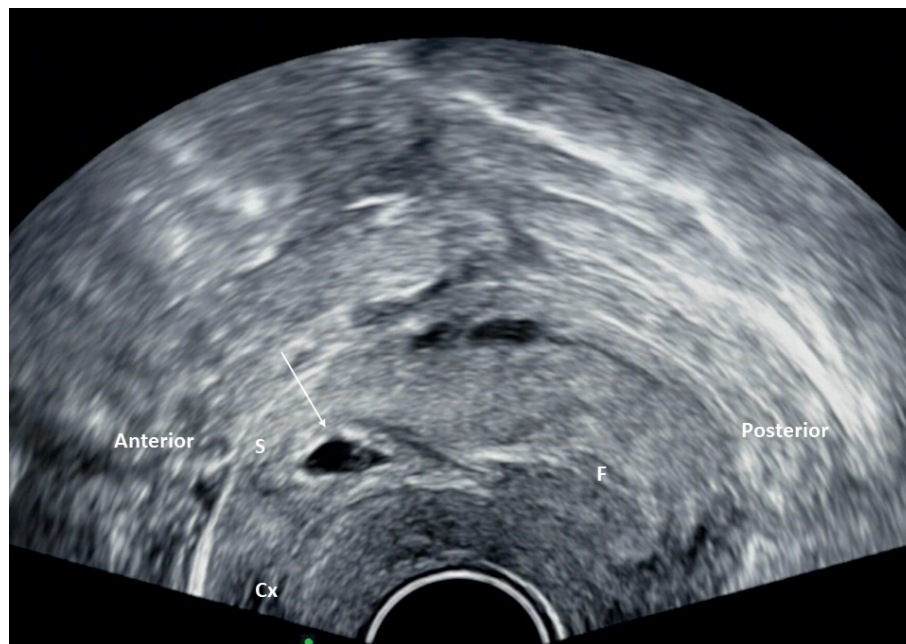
Transvaginal ultrasonography of the patient with caesarean scar pregnancy Transvaginal longitudinal sonogram of the lower uterine wall showing a gestational sac with a yolk sac (arrow) within the wall, at the region of caesarean section scar. The uterine cavity and cervical canal were empty. Cx, cervix; F, fundal endometrial cavity; S, scar of caesarean section.
